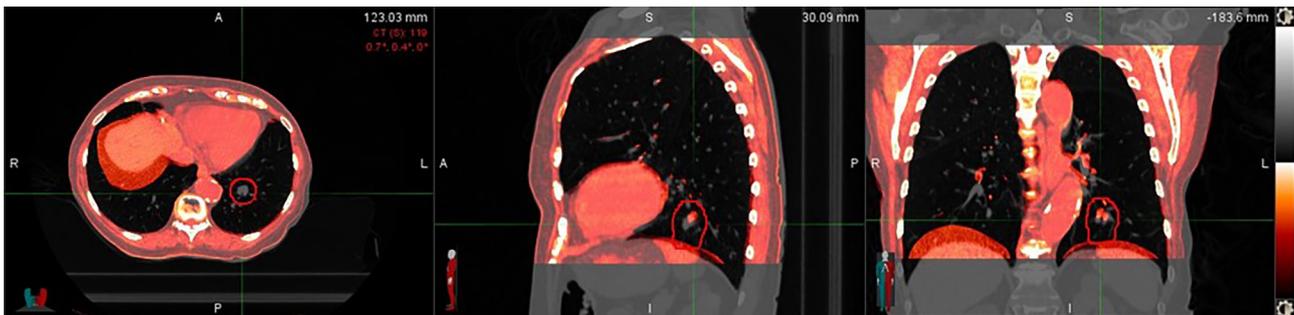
Two CT images acquired at the same threshold (1.2 L). The recorded air volume was 1.30 L (red) and 1.54 L (gray), respectively.
